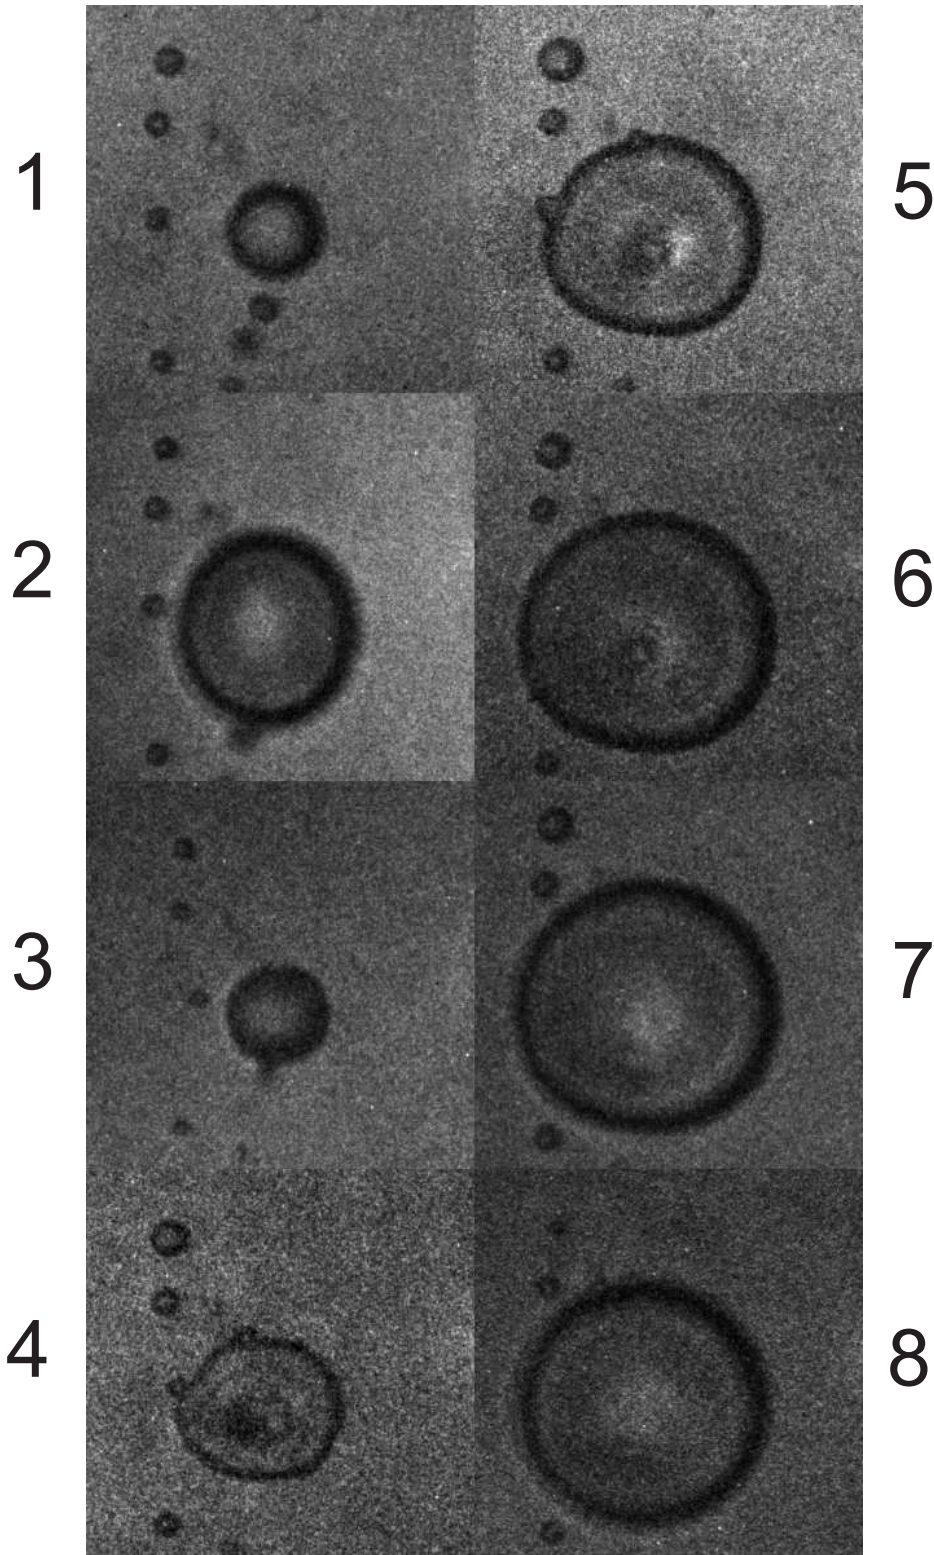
Sequence of high-speed photographs of BR14 contrast microbubbles (Bracco Research SA, Genève, Switzerland) insonified at 0.5 MHz. Frame 1 has been captured prior to ultrasound arrival. The other seven frames cover one full ultrasonic cycle, *i.e.* $2 \mu\text{s}$. Each frame corresponds to a $40 \times 40 \mu\text{m}^2$ area. © 2005 Schiele & Schön GmbH. Reprinted with permission from [20].
